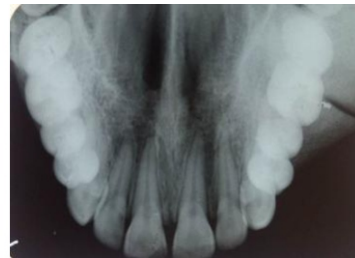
Occlusal radiograph showing the expansion of the left buccal cortical plate
